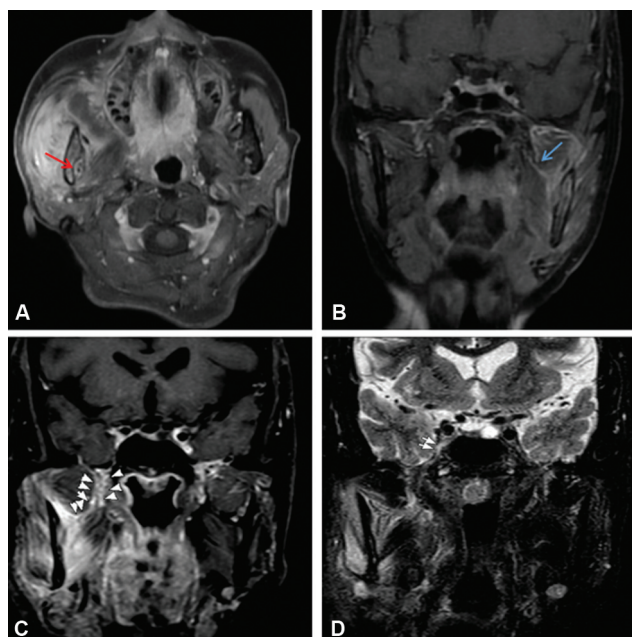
(A) Axial postcontrast magnetic resonance imaging showing right upper Guillain-Barre syndrome mass with associated enhancement along right mandibular nerve in mandibular foramen suggesting perineural spread (red arrow). (B) Coronal postcontrast image showing enhancement along the infratemporal fossa component of the left mandibular (blue arrow). (C and D) Coronal postcontrast image showing enhancement and thickening of the right mandibular nerve involving foramen and suspicious intracranial extension superiorly (white arrowheads and arrow).
